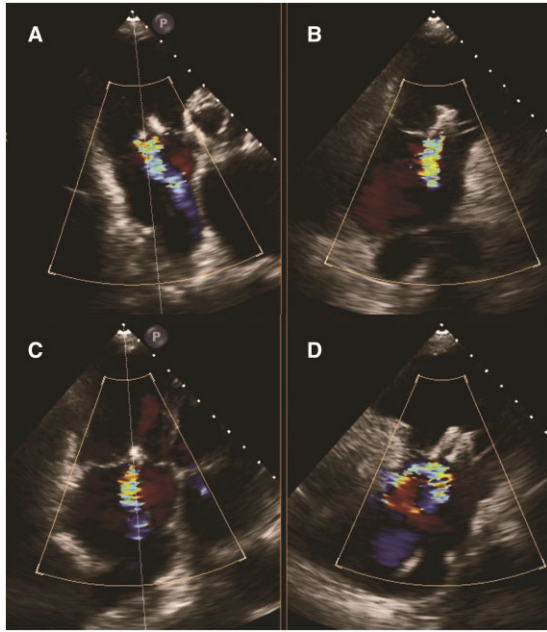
Thirty-day transthoracic echocardiography follow-up showing marked tricuspid regurgitation reduction (A and B) bi-plane colour flow parasternal views. (C and D) Four- and two-chamber views of the right heart.
